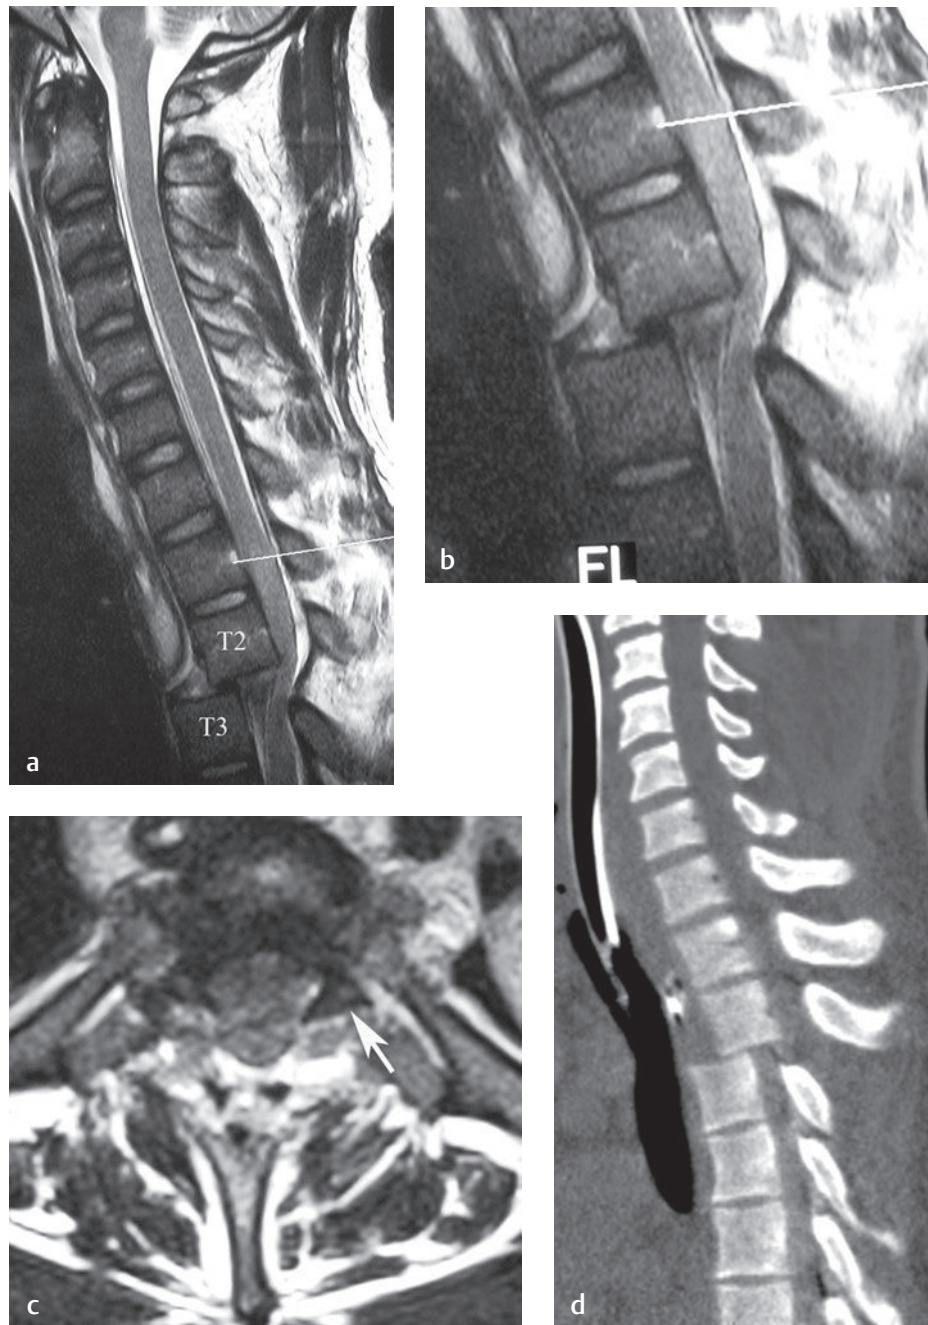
T2-T3 dislocation. This (a) sagittal T2-weighted image and (b) zoom-in show anterior dislocation of T3 relative to T2 without fracture, with resultant severe cord compression, deformity, and acute signal change within the cord; the *line* on each points to the T1 vertebral body. (c) An axial T2-weighted image shows that the facets are “naked” or dissociated, a finding better seen on the left side (*arrow*). (d) A sagittal reconstructed CT image also shows the dislocation and confirms the absence of a fracture.[†]
